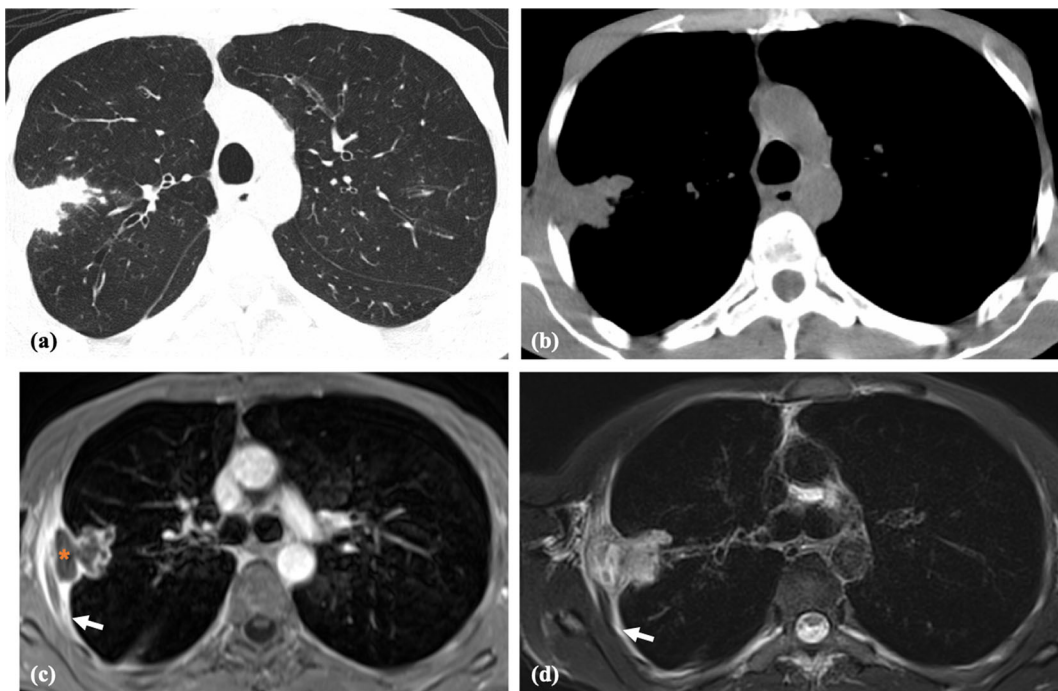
SAIA in a 46-year-old male diagnosed with AIDS presenting with constitutional symptoms, dry cough and chest pain for about two months. Axial CT in lung (a) and mediastinal (b) windows depict an irregular and spiculated mass in the right upper lobe associated with pleural thickening. Post-contrast T1FS (c) and T2FS (d) MRI images reveal the necrotic nature of the mass, lacking enhancement in the center (orange asterisk)
